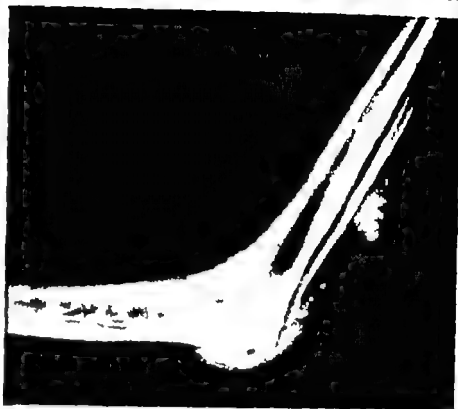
(A *Left*) Male, aged 21 with ankylosis of the right knee in severe recurvatum (B *Right*) Roentgenogram of the knee depicted in A. Note the presence of a wire. The reason for its use was never established.
